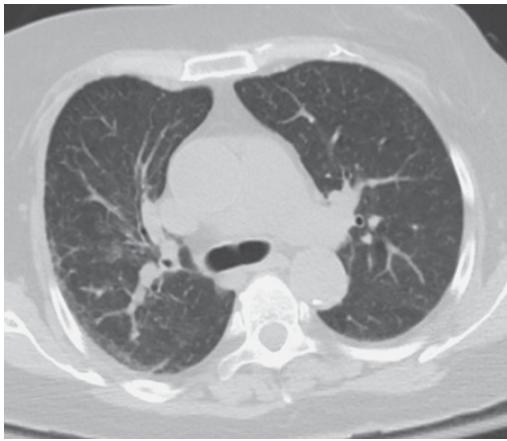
Chest CT scan showing nodules with “tree-in-bud” pattern in bilateral upper lobes.
